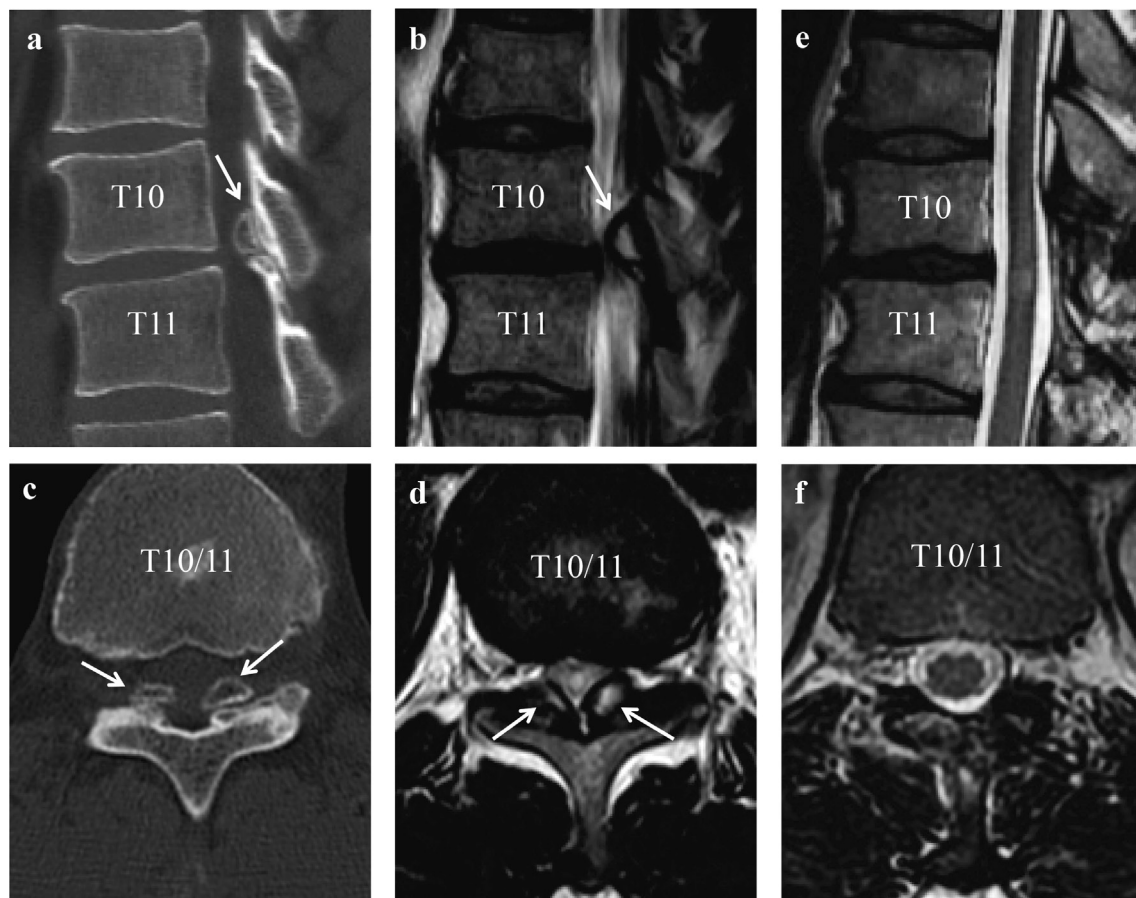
Pre- and postoperative CT and MRI findings of Case 2. Sagittal CT (a) and MRI (b), axial CT (c) and MRI (d) show OLF at T10/11 (arrows). Satisfactory decompression is achieved after the spinous process-splitting approach (e), and there is no evidence of muscle damage (f).
